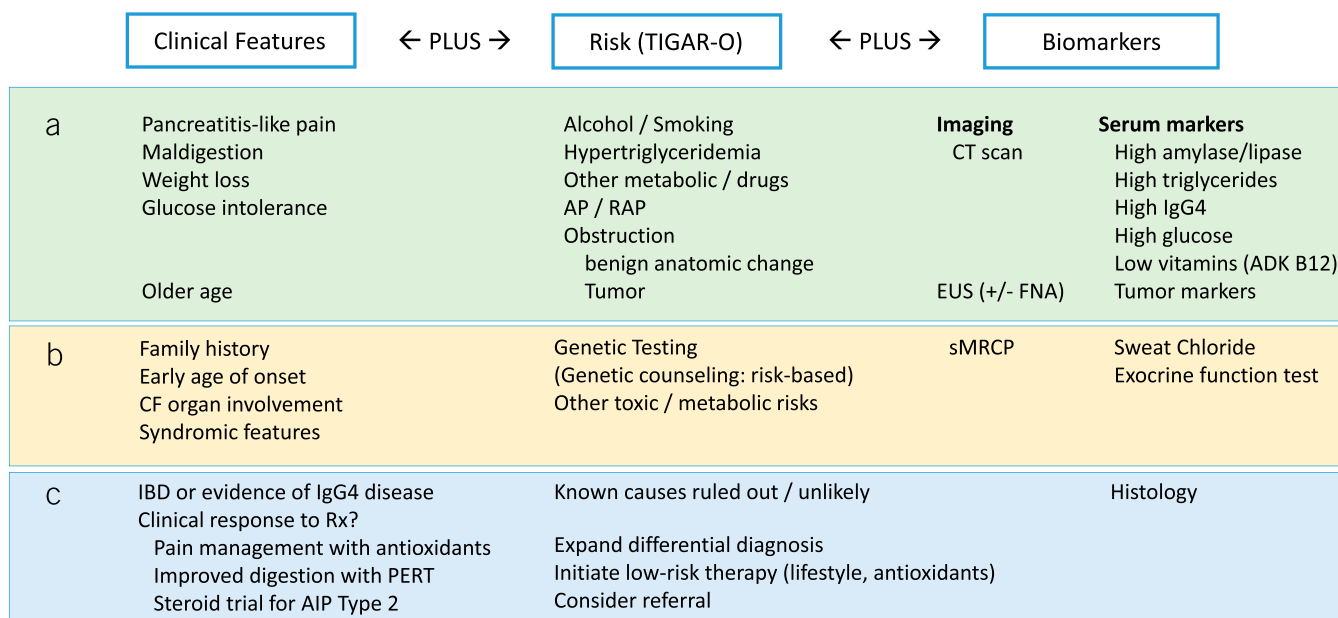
Conceptual diagnostic algorithm based on the new mechanistic definition of disease. With clinical suspicion of disease, this algorithm suggests the concordance of 3 features (clinical, risk, and biomarkers) to make a diagnosis, and it divides the approach into 3 levels of investigation (A, B, and C). Once a diagnosis is made, then the progressive workup can focus on issues related to management. AP, acute pancreatitis; AIP, autoimmune pancreatitis; CF, cystic fibrosis; CT, computed tomography; EUS, endoscopic ultrasonography; FNA, fine needle aspiration; IBD, inflammatory bowel disease; PERT, pancreatic enzyme replacement therapy; RAP, recurrent acute pancreatitis; Rx, therapy; s-MRCP, secretin-enhanced magnetic resonance cholangiopancreatography.
